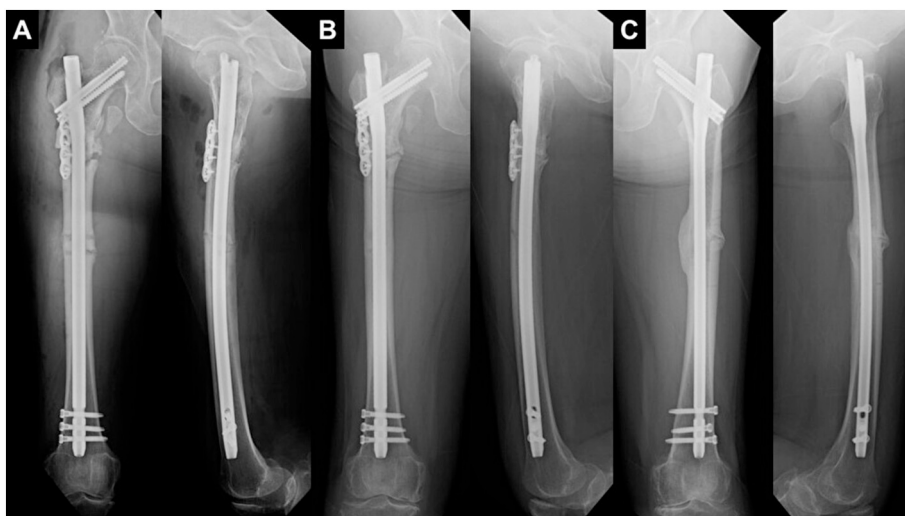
Radiographs after the revision surgery and at the final follow-up. (A) A long-length nail is inserted after realignment and provisional plate fixation of the subtrochanteric lesion. (B) One and a half years after the revision surgery, bony union of the diaphyseal lesion is obtained, but the subtrochanteric lesion is not healed. (C) Two years after the surgery, bony union of the diaphyseal lesion is obtained.
